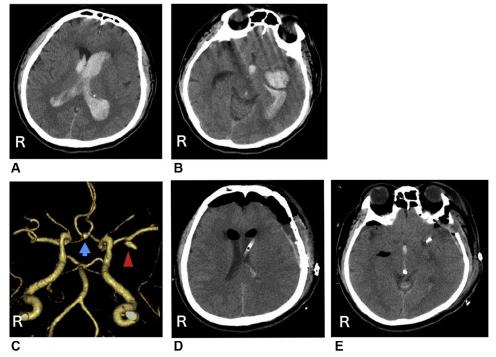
Pre- and postoperative computed tomography (CT). (A) Preoperative head CT shows hydrocephalus caused by intraventricular hematoma. (B) Preoperative head CT shows subarachnoid hemorrhage with intracerebral hematoma. (C) Three-dimensional CT angiography shows aneurysm of the anterior communicating artery (3×3 mm, blue arrow) and left middle cerebral artery aneurysm (3×7 mm, red arrowhead). (D and E) Postoperative day (POD) 1 CT did not show a low-density area. (Color version of figure is available online.)
